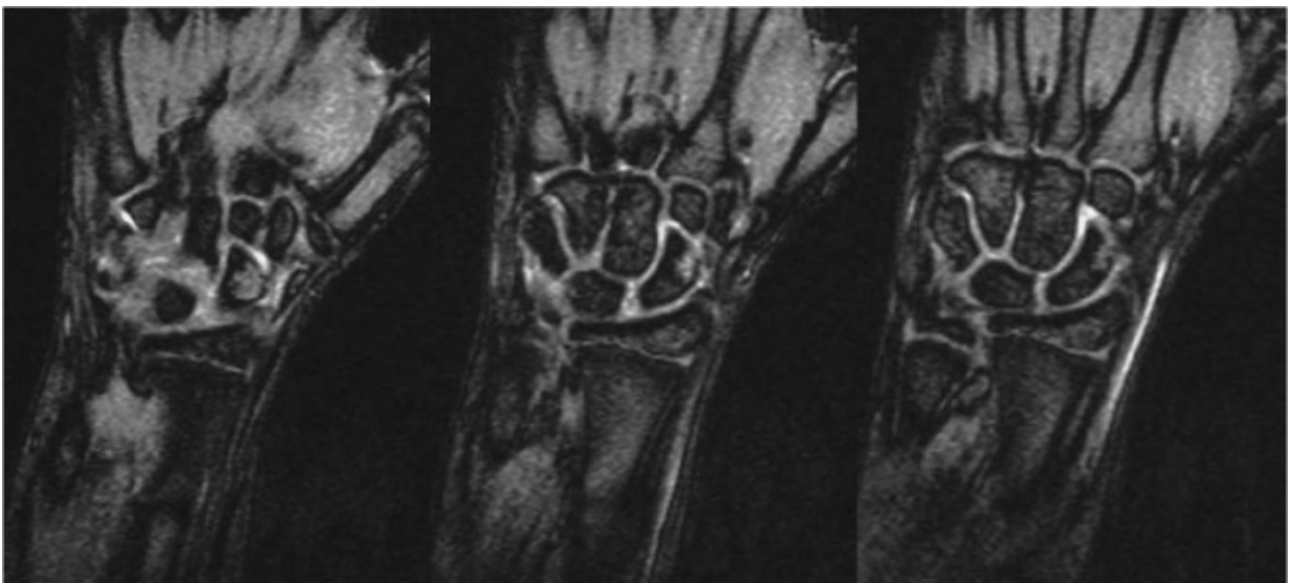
An 11-year-old boy with a radiographically occult scaphoid injury following a fall from his bicycle that was immobilized in plaster. A MRI was performed due to residual symptoms, following cast removal, 5 weeks post-injury. FL2D images showed bone bruising of the distal pole of the left scaphoid and fluid signal around it.
